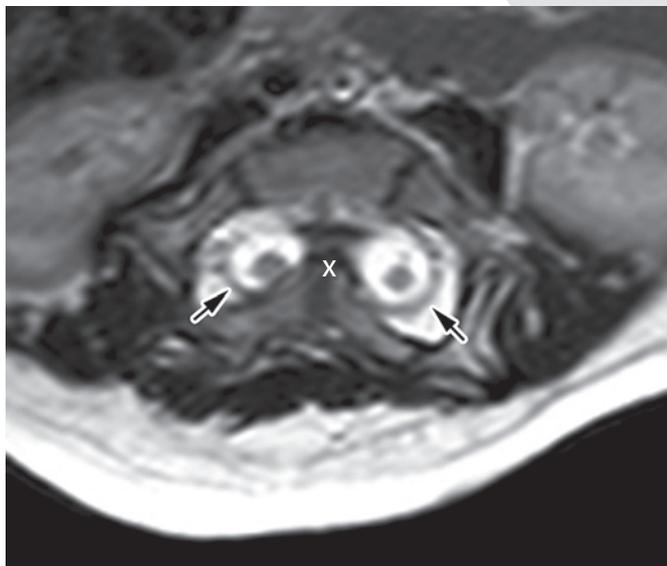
The “owl eyes sign” on a T2-weighted axial MR image. Note the double dural tube (arrows) and a large septum (X) between the two hemicords.
